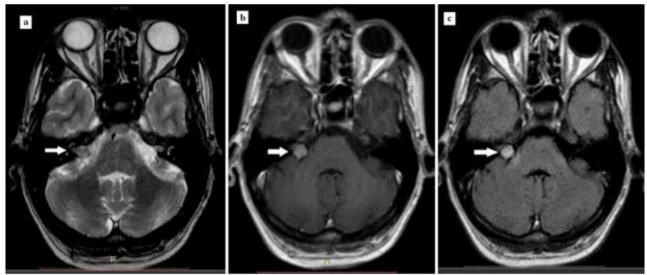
Axial T2W image (a) and FLAIR image (b) shows a hyperintense well defined rounded lesion in the right CP angle cistern (*arrow*), adjacent to the right IAC. Post contrast T1W axial image (c) shows marked homogenous enhancement of the lesion
